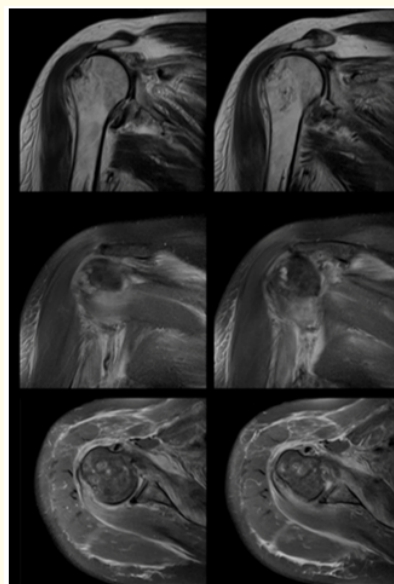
Right Shoulder MRI after 1 month, showing articular effusion, supraspinatus tear, subtle biceps subluxation and synovitis. Suitable articular congruency.
